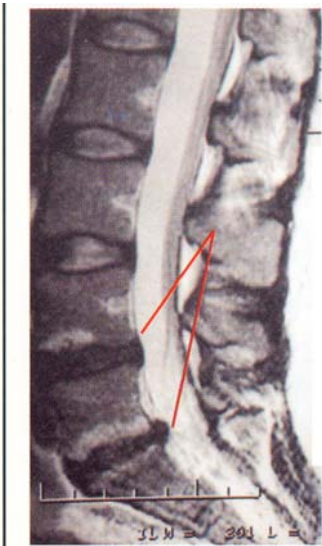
MRI of lower back showing degeneration of the lowest two discs. This is a common finding on patients and may not relate to their pain. There is no pinching of nerves in the spine. Not suitable for surgery.
